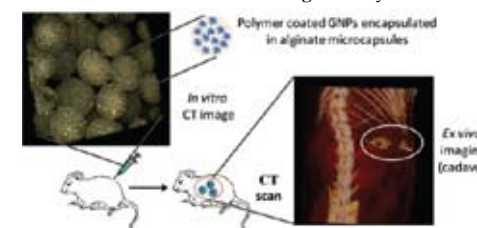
3D rendering based on X-ray CT imaging of GNPs loaded alginate MCs.
